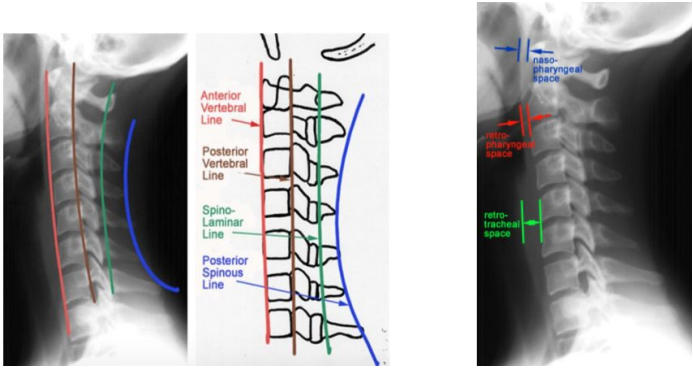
Cervical spine – normal X-ray findings (a) In the lateral projection, the radiological lines are: 1 soft-tissue line; 2 anterior vertebral body line; 3 posterior vertebral body line; 4 spinolaminar line. 5 The lines of convergence are drawn down the spinous processes and should converge posteriorly; these help identify posterior element disruption. (b) AP view confirms alignment of the spinous processes. (c) Open-mouth view should show a centrally placed dens with congruous and symmetrical C1/C2 lateral mass joints.
